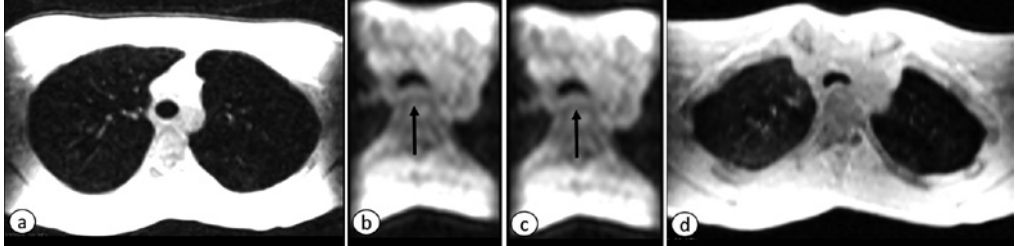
Tracheomalacia assessment with cine-MRI. 3D SPGR axial at end-inspiration (a), SPGR with Time Resolved Imaging of Contrast KineticS (TRICKS) dynamic during forced expiration (b), and coughing maneuver (c); 3 D SPGR axial at end expiration (d). Note increased collapse during breathing maneuvers compared to end expiration scan.
